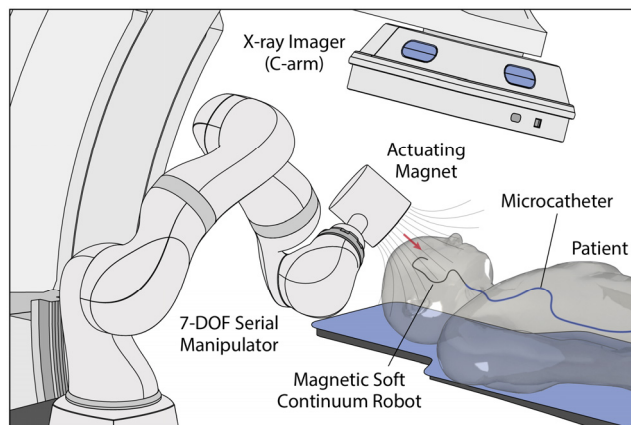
Telerobotically controlled magnetic soft continuum robot in the neurovasculature based on spatial positioning of an actuating magnet at the end of a 7-DOF serial manipulator under real-time x-ray fluoroscopy.
